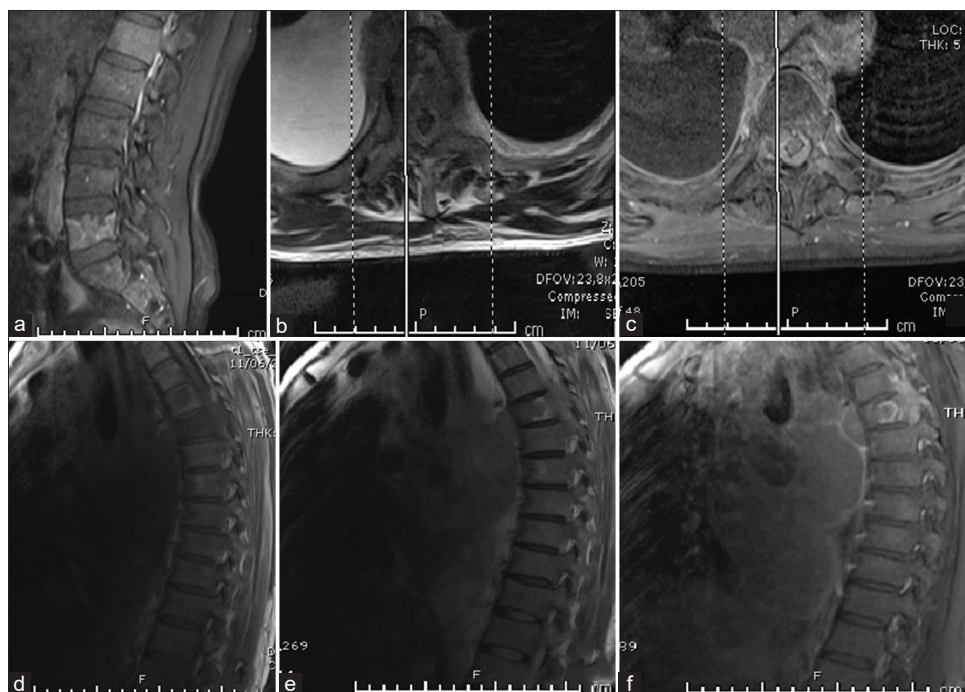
Lumbar and thoracic magnetic resonance images of a 54-year-old male patient who experienced dramatically developed paraparesis (last 1 week) and low back and both legs' pain for 1 month. The patient had a history of malign hepatocellular carcinoma for more than 2 years; (a) Sagittal contrast-enhanced T1-weighted image sequence of lumbar magnetic resonance imaging showed multiple involvements of L1, L2, L5, and S1 vertebral bodies. These vertebral bodies showed heterogeneous contrast enhancement. (b) Axial T2-weighted image of thoracic magnetic resonance imaging showed T5 vertebral body. (c) Axial T2-weighted image of thoracic magnetic resonance imaging showed T5 vertebral body was involved with heterogeneously contrast-enhanced hyperintense lesion extended to epidural space. Tumor mass surrounded the spinal cord like a muff. (d) Sagittal T1-weighted image sequence of thoracic magnetic resonance imaging showed multiple involvements of T4 and T5 vertebral bodies. Lesions were hypointense on T1-weighted image sequence. (e) Sagittal T2-weighted image sequence of thoracic magnetic resonance imaging depicts the "halo sign" with a hypointense metastatic lesion and a surrounding hyperintense rim in the T5 vertebral body. (f) Sagittal contrast-enhanced T1-weighted image sequence of thoracic magnetic resonance imaging showed multiple involvements of T4 and T5 vertebral bodies. Note that rim be more apparent with contrast. He underwent the operation of STR and posterior instrumentation. The patient died on PO 5th month after involved with pneumonia
